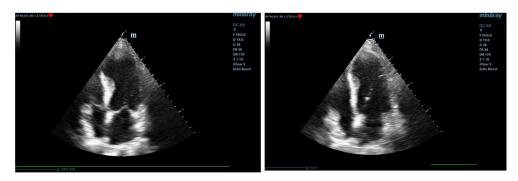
Apical aneurysm noticed in a case with myocardial infarction ten days later (2D, apical 4-chambers view)
